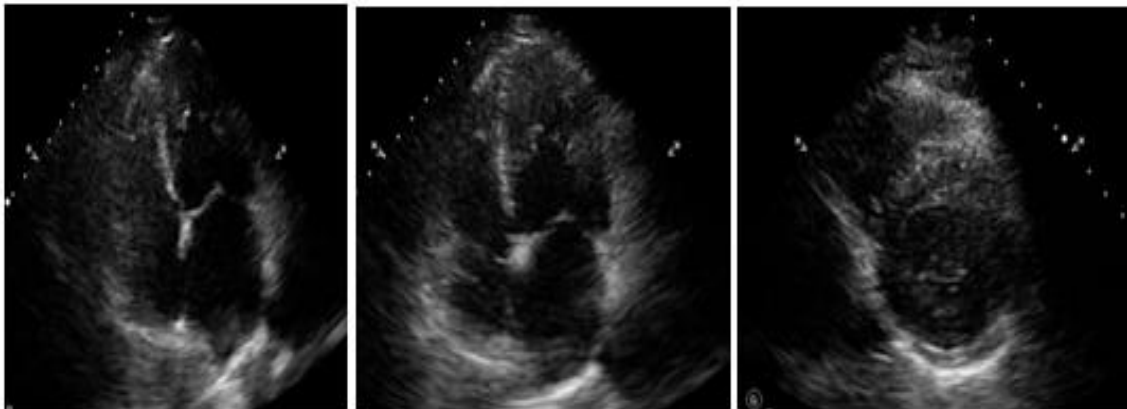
2D echocardiography: apical four-chamber (A4c) and short axis showing trabeculation of the apex, the medium and apical segment of the interventricular septum, and the lateral wall
